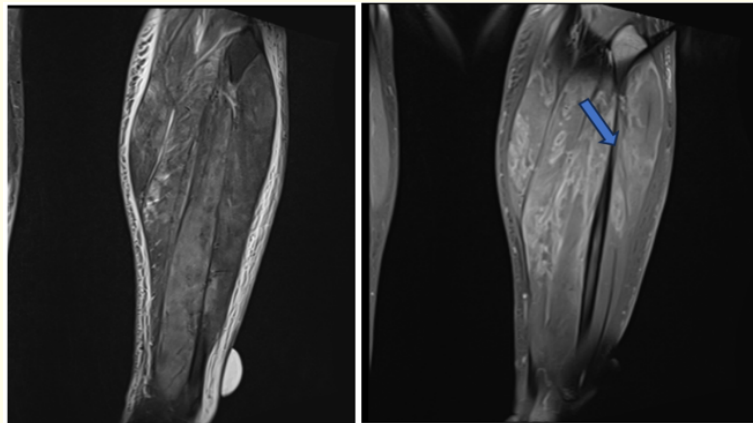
MRI of the left lower limb. Coronal T2-weighted STIR image (A) demonstrates diffuse muscle edema involving multiple muscle compartments, associated with extensive subcutaneous edema. Contrast-enhanced fat-suppressed T1-weighted image (B) shows multiple non-enhancing areas of muscular necrosis surrounded by peripheral enhancement, with numerous punctate enhancing foci within the necrotic muscle, producing the characteristic "stipple sign" (Blue arrow).
